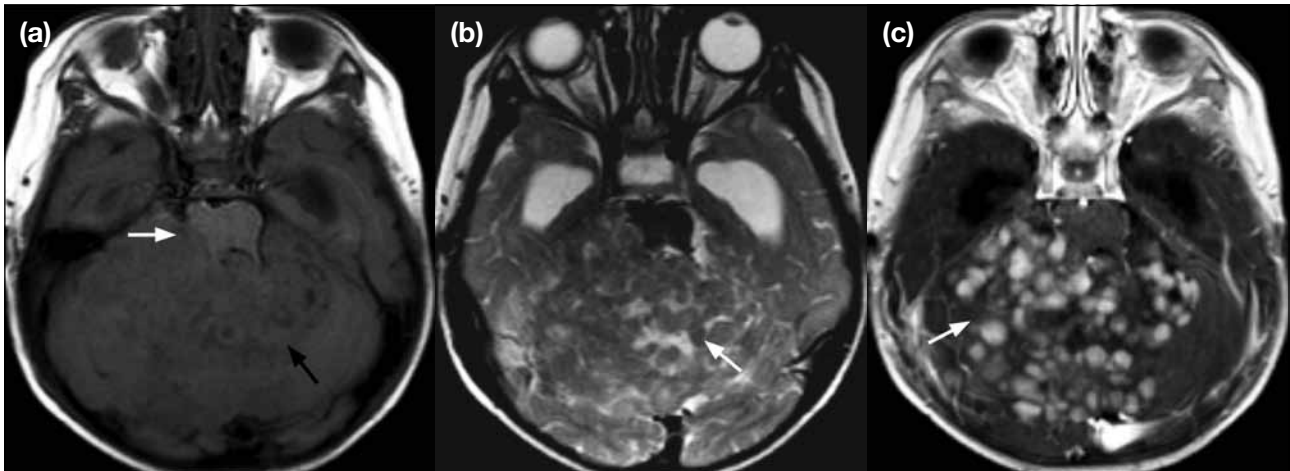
A 14-month-old boy presented with a generalised convulsion and underwent magnetic resonance imaging of the brain. (a) Axial T1-weighted image shows an ill-defined multi-nodular mass, isointense to grey matter (black arrow) causing a mass effect onto the brainstem (white arrow). (b) Axial T2-weighted image shows the nodular appearance of this large heterogeneous intensity lesion (white arrow) in the cerebellum. (c) Contrast-enhanced T1 axial image shows avid nodular enhancement (white arrow) of the lesion.
